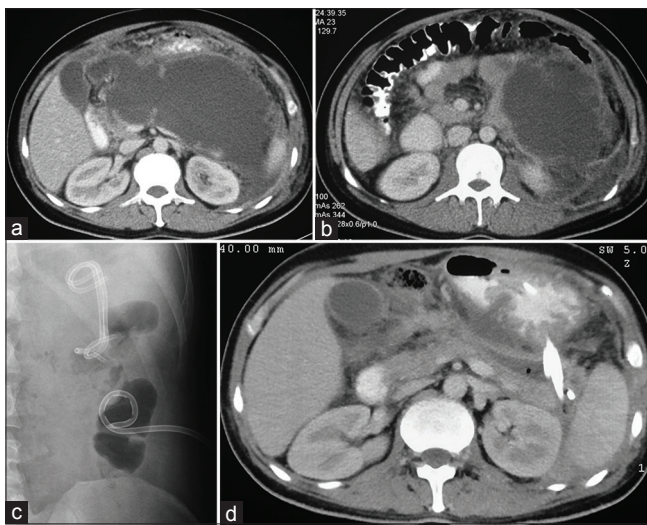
Patient with both central and peripheral necrosis with percutaneous catheter drainage catheter in peripheral necrosis. (a) Computed tomography abdomen: Large central necrotic collection that has not got walled off. (b) Computed tomography abdomen: A large peripheral necrotic collection. (c) AxR after percutaneous followed by endoscopic transmural drainage. Both transmural stents as well as percutaneous catheter is seen. (d) Computed tomography shows resolution of walled off pancreatic necrosis with transmural stents *in situ*. The percutaneous catheter has been removed
